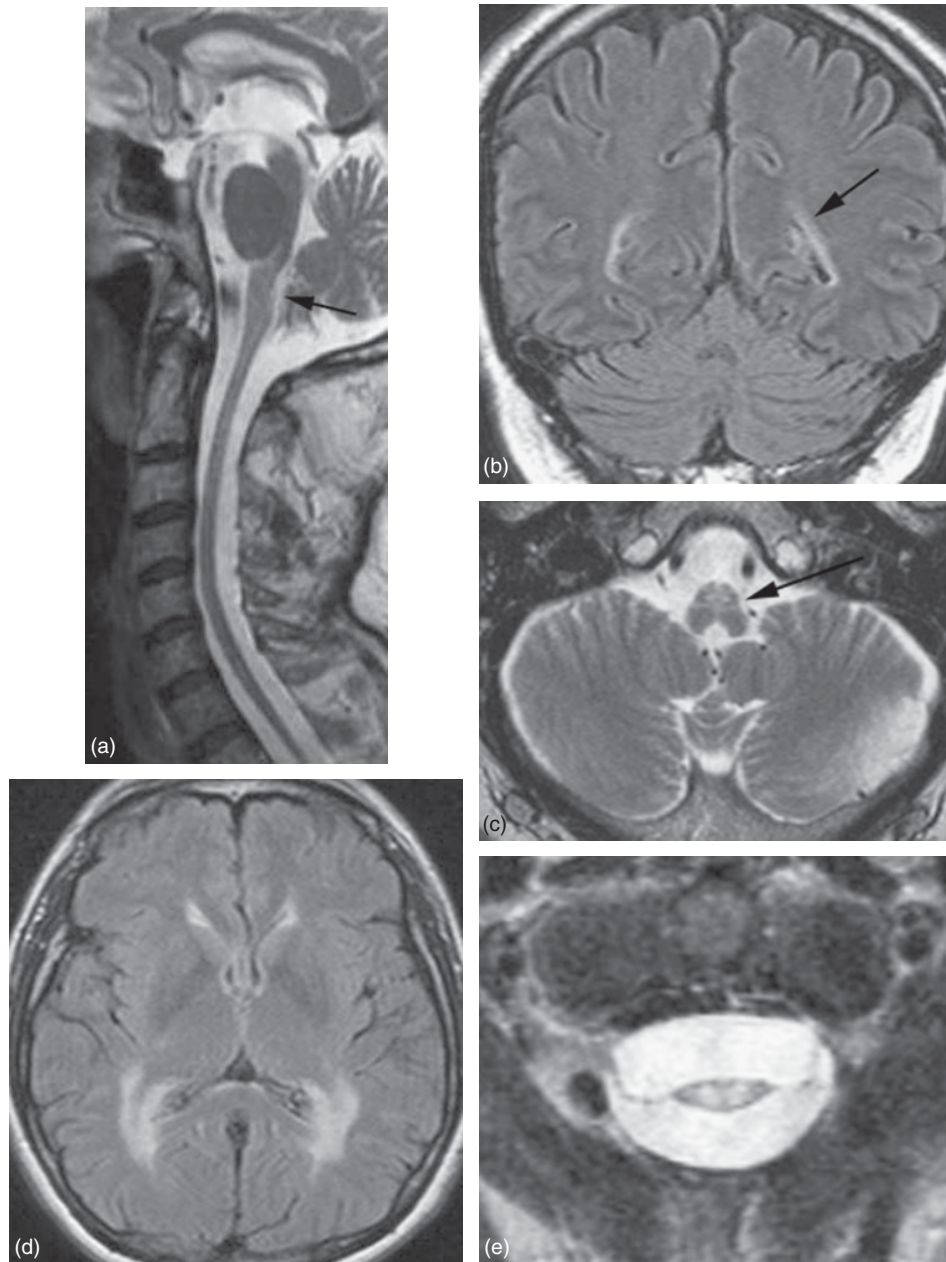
Representative MR images of characteristic lesions of AOAD from patients ranging in age from 43 to 64-years old. T2-weighted midline sagittal section shows (a) atrophy and signal abnormalities in the medulla oblongata (arrow); the hyperintensity fades away in the upper cervical spinal cord, whereas the entire spinal cord is also atrophic. Axial FLAIR image shows (b) increased signal intensity of the periventricular white matter, more extensive in the posterior regions. Coronal FLAIR section shows (c) very thin posterior periventricular abnormalities (arrow on the left) not detected by T2-weighted sequences (not shown). Axial T2-weighted section demonstrates (d) signal hyperintensities in the atrophic anterior part of the medulla oblongata (arrow). Axial T2-weighted section on the cervical spinal cord shows (e) severe atrophy and signal changes at C1–C2 level.
